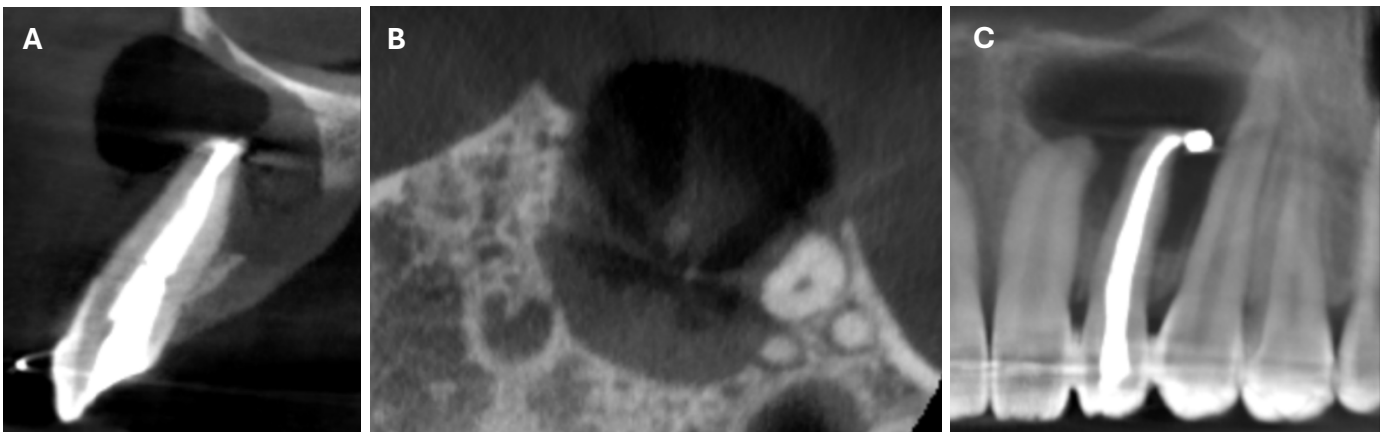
Cone beam computed tomography (CBCT) of tooth 22 (upper left lateral incisor). (A) sagittal plane; (B) axial plane; (C) panoramic view from CBCT. CBCT as of 2018.
